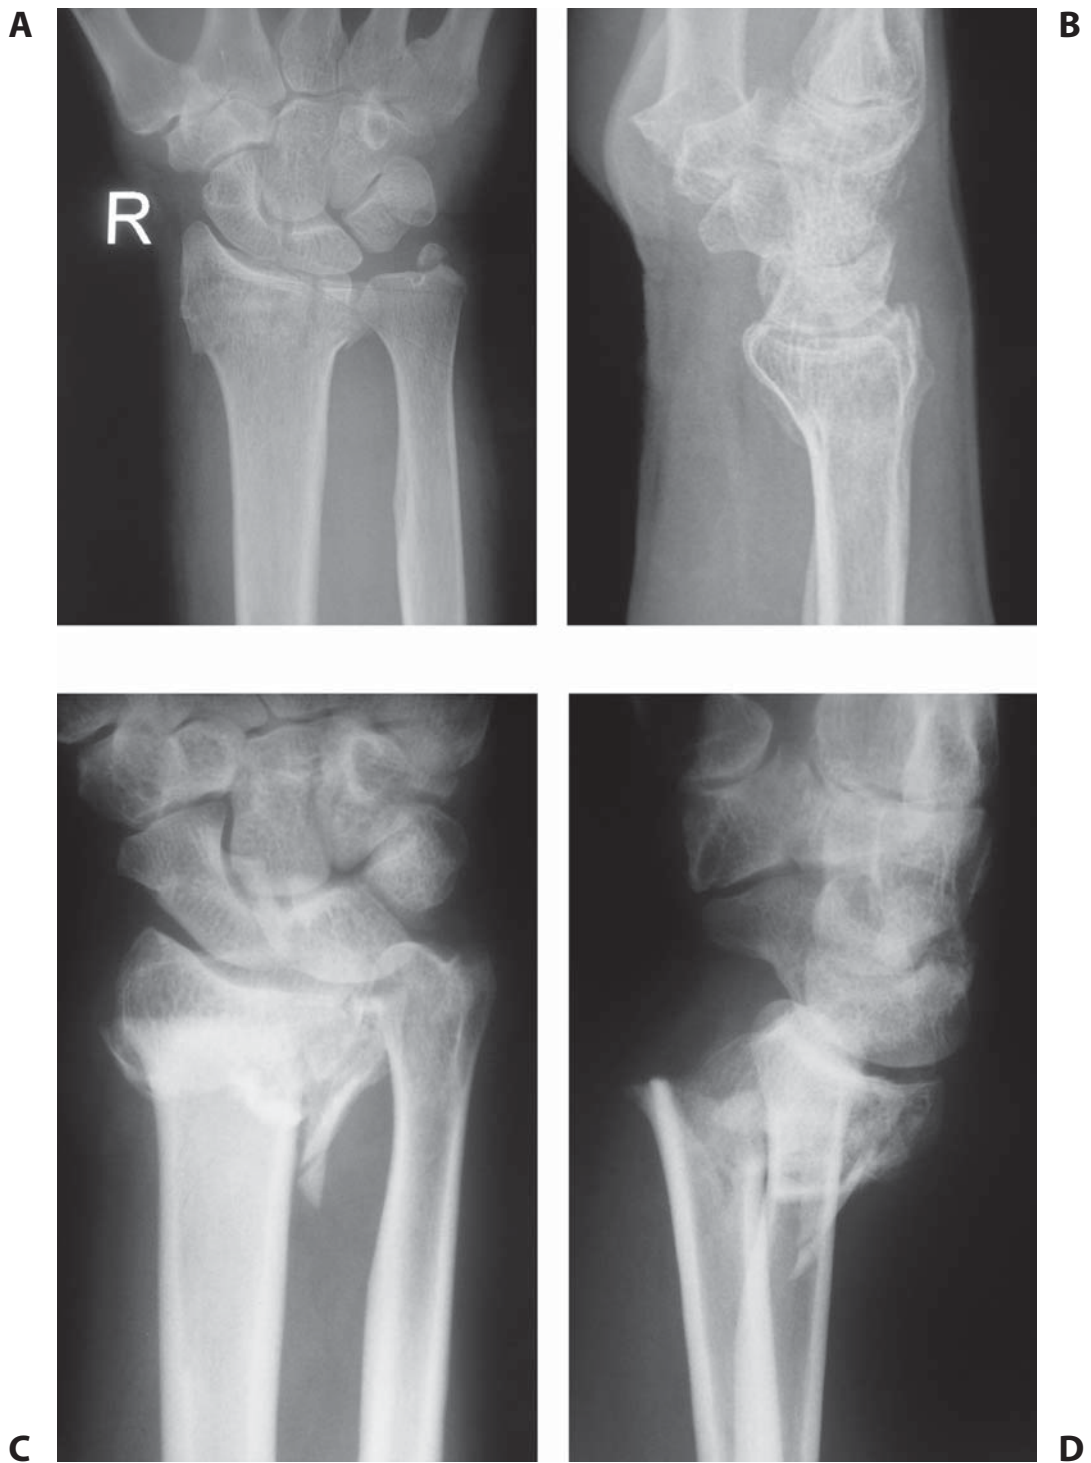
A radiographic image of a radial fracture in antero-posterior (A) and lateral (B) views; C, D – distal radius fracture – type C3.
